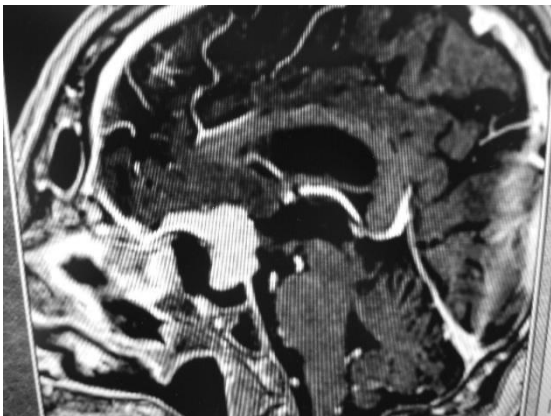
MRI (sagittal view) of a suprasellar meningioma affecting planum sphenoidale and right cavernous sinus.
